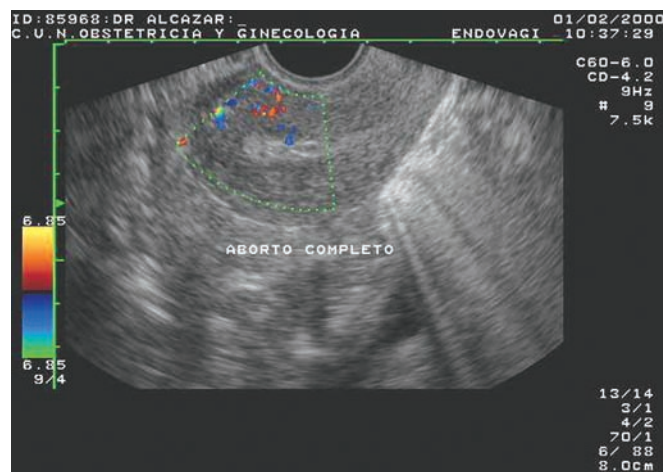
Transvaginal color Doppler ultrasound after heavy vaginal bleeding in first trimester. Scanty flow was found, suggestive of no retained tissue.
